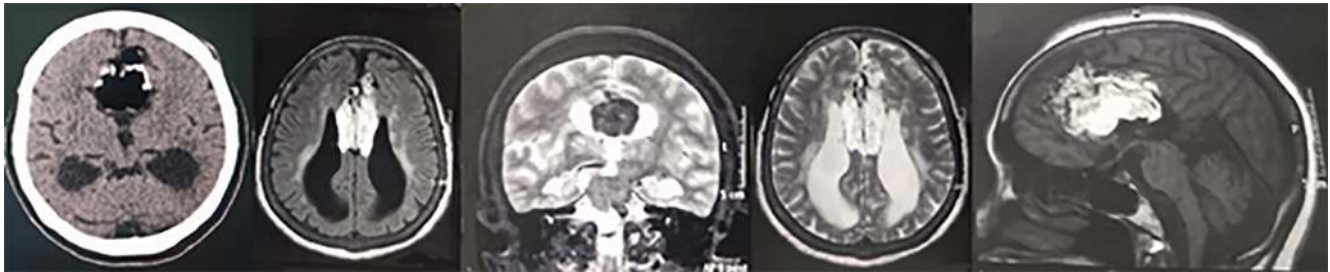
(A) CT. (B) Axial RNM T1W. (C) Coronal RNM T2W. (D) Axial RNM T2W. (E) Sagittal RNM T1W. Frontal median lesion of fat content measuring about 6.6 x 4.5 x 3.5 cm associated with signs of corpus callosum dysgenesis and colpocephalic aspect of the lateral ventricles.
